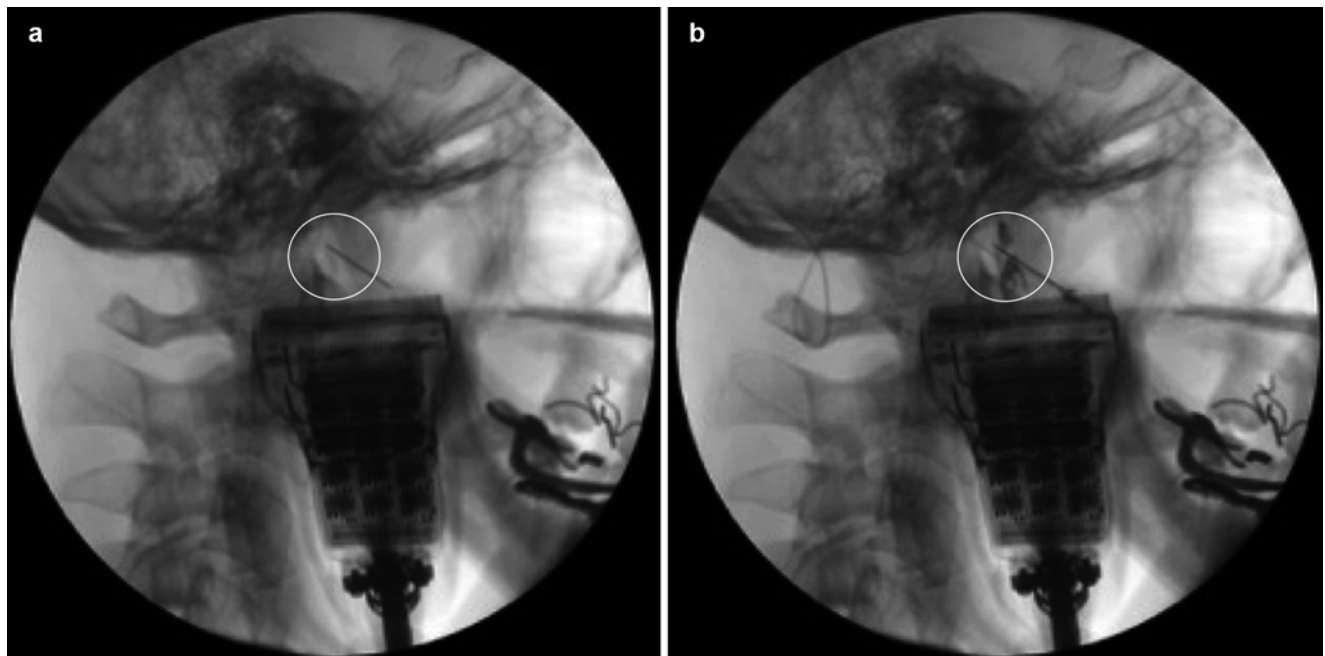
Combined fluoroscopy/ultrasound images showing the glossopharyngeal nerve injection, with needle seen within the *white circle*. (a) Needle placement; (b) injection of contrast (Image courtesy of Christ DeClerck, MD)
